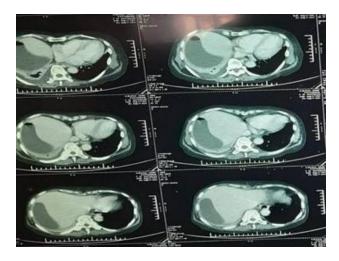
CT abdomen showing subdiaphragmatic abscess.
